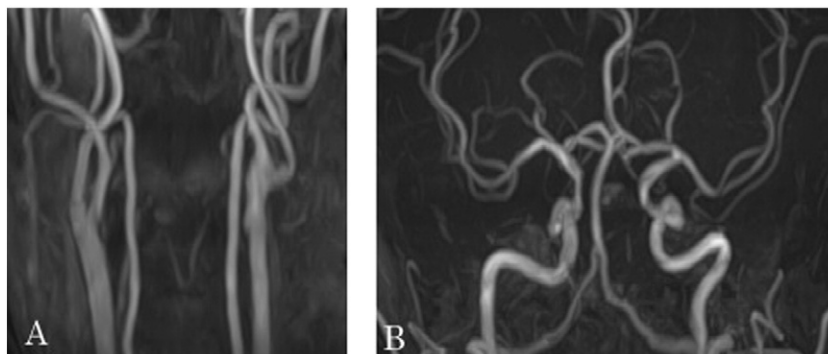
Radiographic findings for Case 1 one year after surgery. A,B: a patent left CA was confirmed on cervical and cranial MRA.
